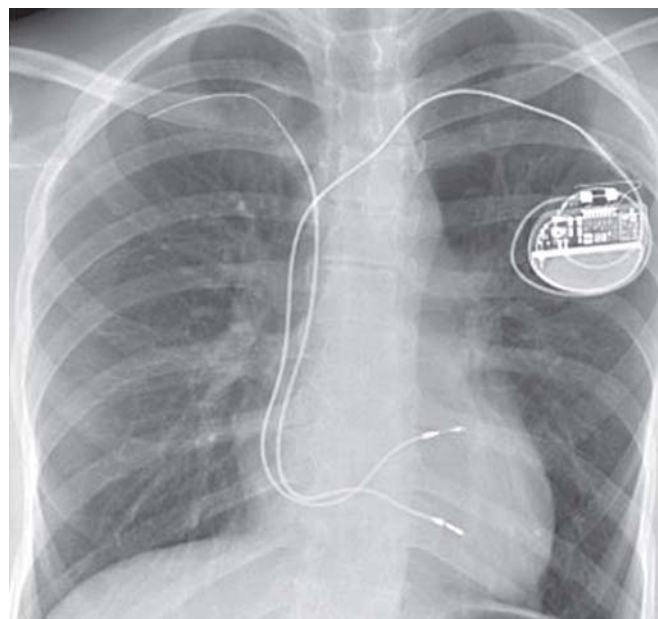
Chest X-ray showing abandoned lead on the right side and the left-sided VVI system
